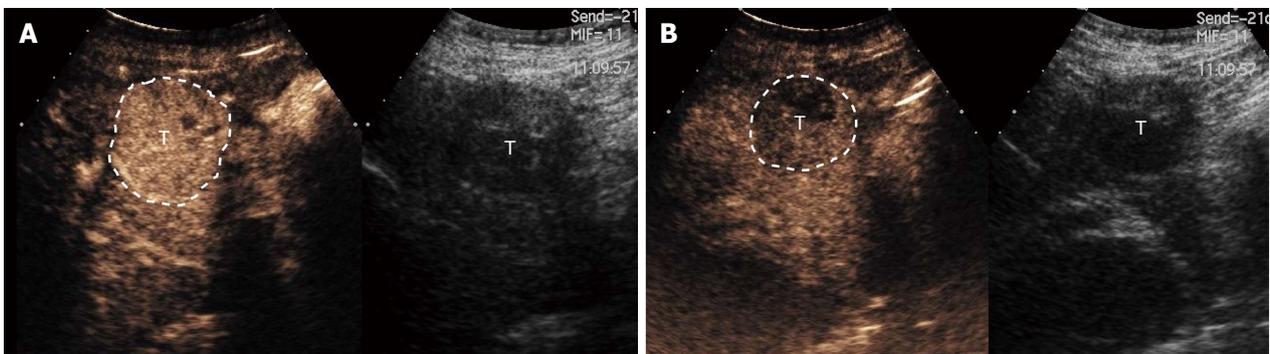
Ultrasound of hepatocellular carcinoma. A: Ultrasound of the liver demonstrates a heterogeneous tumor (T) in the right lobe of the liver that was later characterized as definite hepatocellular carcinoma by computed tomography; B: Same lesion (T) using color Doppler ultrasound images to demonstrate blood flow in the adjacent vessels.
